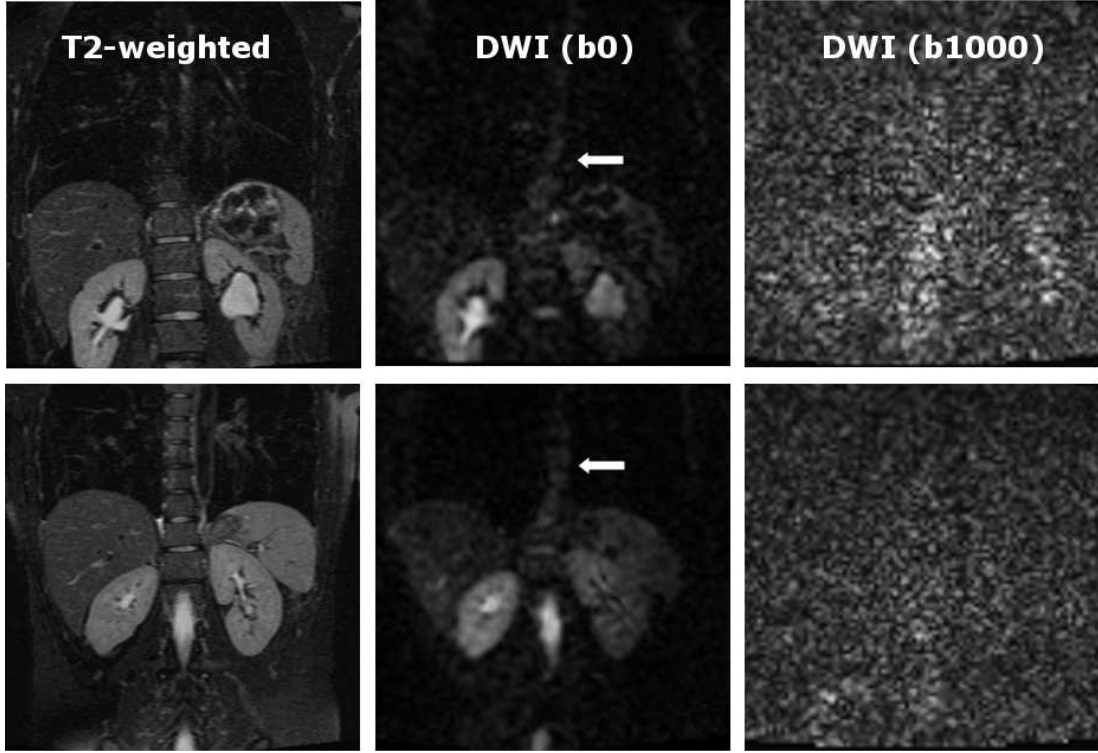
The abdominal T2, DWI  $b_0$  and  $b_{1000}$  images for subject 3 (top) and subject 5 (bottom). The DWI images are distorted, especially the images where  $b = 1000 \text{ s/mm}^2$  ( $b_{1000}$ ). There are spatial distortion with the  $b_0$  images as indicated by the presence of the curved spinal column (arrows).
